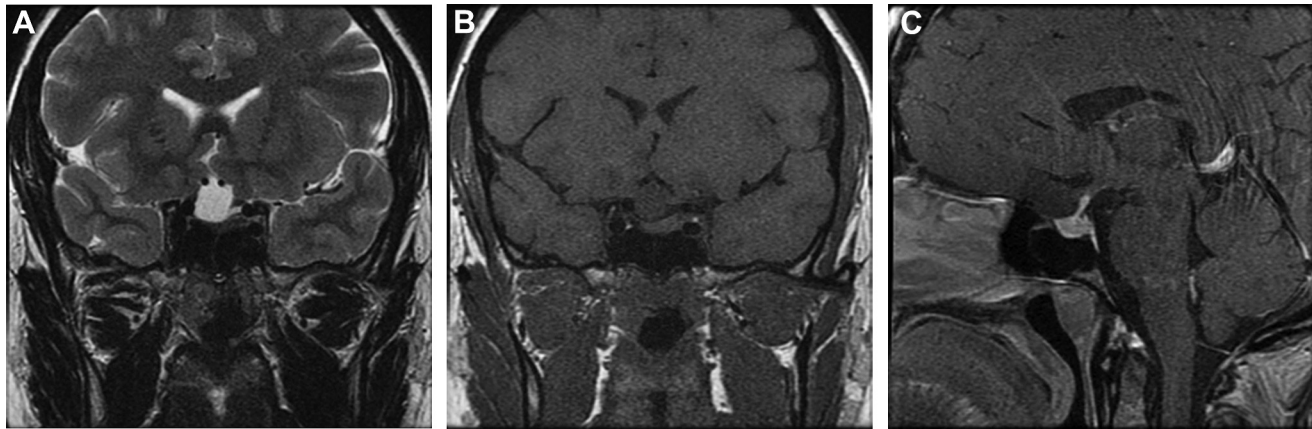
Coronal T1 (A) and T2 (B) magnetic resonance imaging demonstrating the homogeneous appearance of cyst beneath paired
